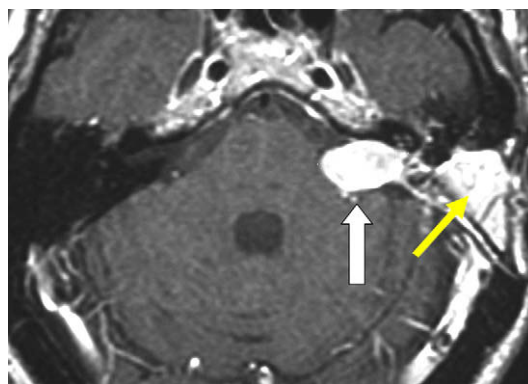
Axial postcontrast T1-weighted image obtained 4 years after TL resection of AS. Note the recurrent tumor with early brainstem compression (*white arrow*). Fat fills the translabyrinthine defect (*yellow arrow*).
